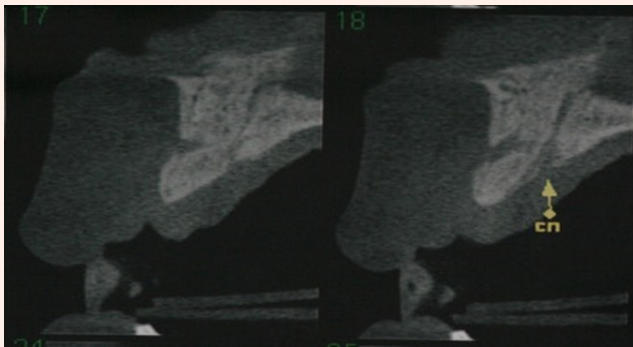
CBCT images showing the growth of bone with distraction.
